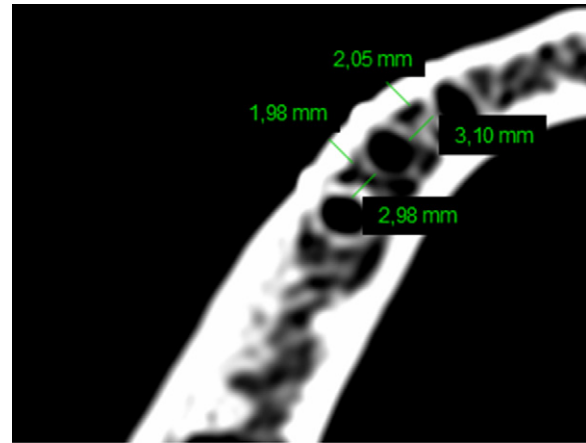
Axial computed tomogram showing measurements of the inter-radicular distance and thickness of the vestibular cortical bone.
